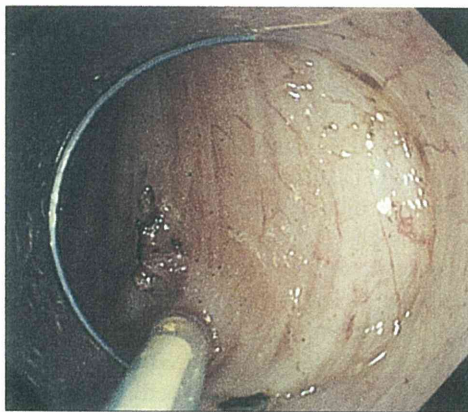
The NBVV was observed in the center of the post-ESD ulcer, and because there was no Doppler signal, the vessel was not treated.
